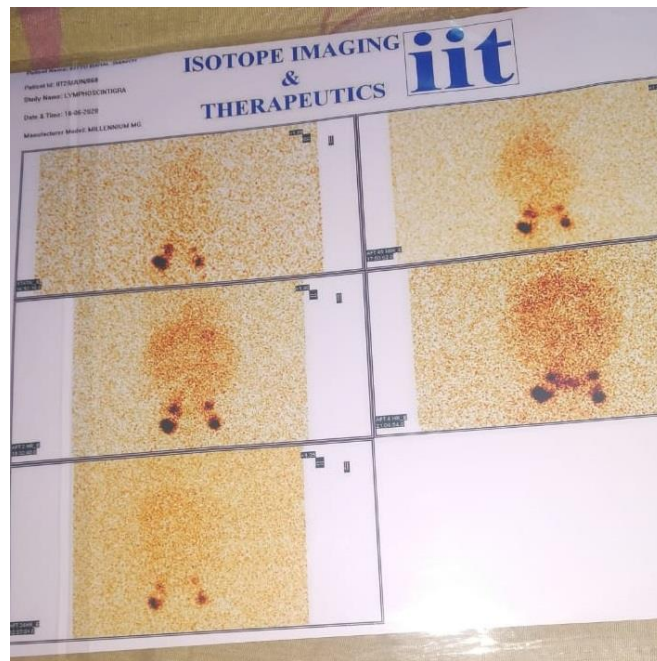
Lymphoscintigraphy
